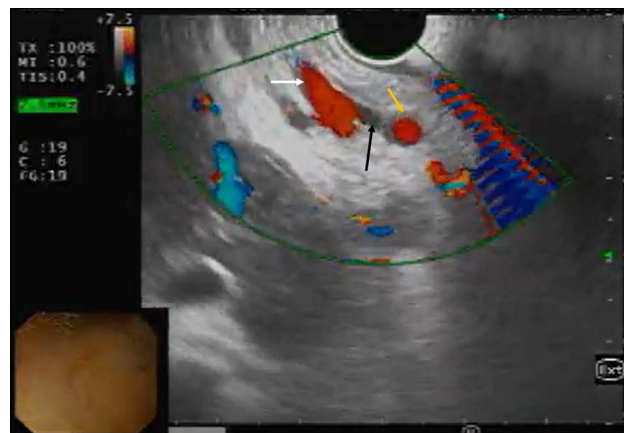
Endoscopic ultrasound images showing intracholedochal (yellow arrow) and pericholedochal varices (white arrow) around the common bile duct (black arrow).
